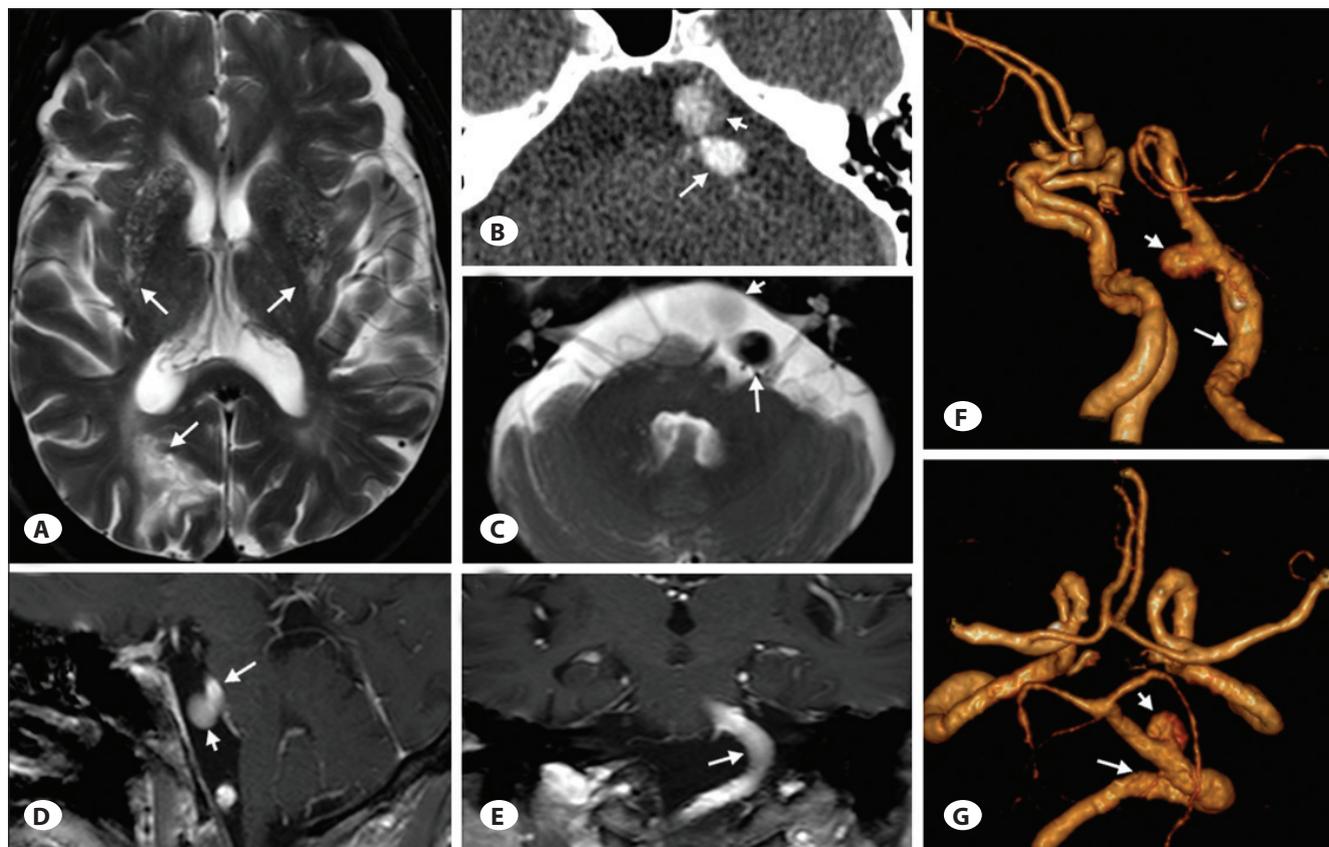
Axial (A) T2 Weighted MRI showing multiple infarcts of bilateral basal ganglia and right occipital lobe (arrows). Gadolinium-enhanced CT (B) and T2 Weighted MRI (C) showing VBD (arrow) compressed the left pons and the root exit zone for the facial nerve (C) and aneurysm (short arrow) with plaque (B). Sagittal (D) and coronal (E) MRA images and Volume rendering technique (VRT) images (F, G) showing VBD (arrow) and the aneurysm (short arrow).
